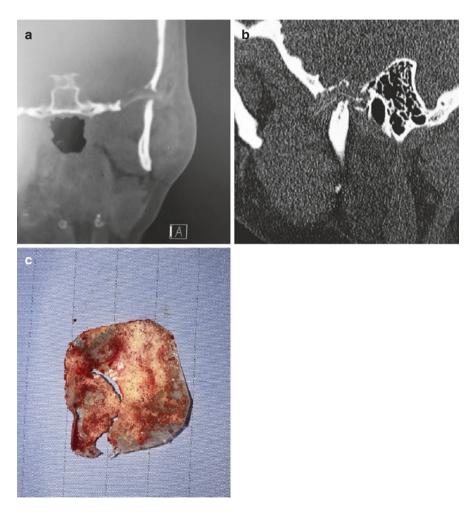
(a) Coronal and (b) sagittal view of a CT scan demonstrating a Proplast implant within the TMJ resulting in erosion into the middle cranial fossa. (c) Explanted Proplast with evidence of significant wear leading to material perforation and implant fragmentation
